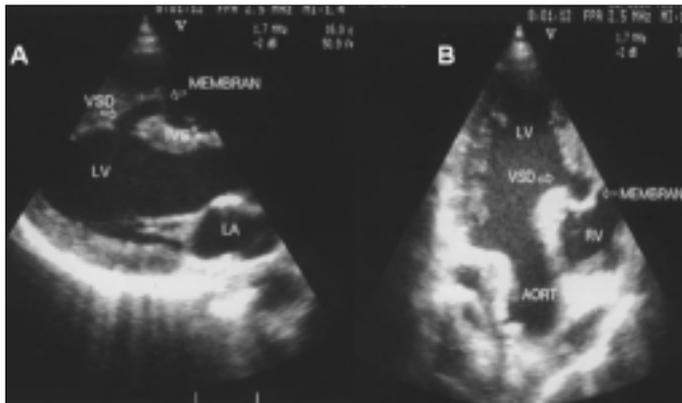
Parasternal long axis (A) and apical (B) echocardiographic views depicting the ventricular septal defect and the membrane
